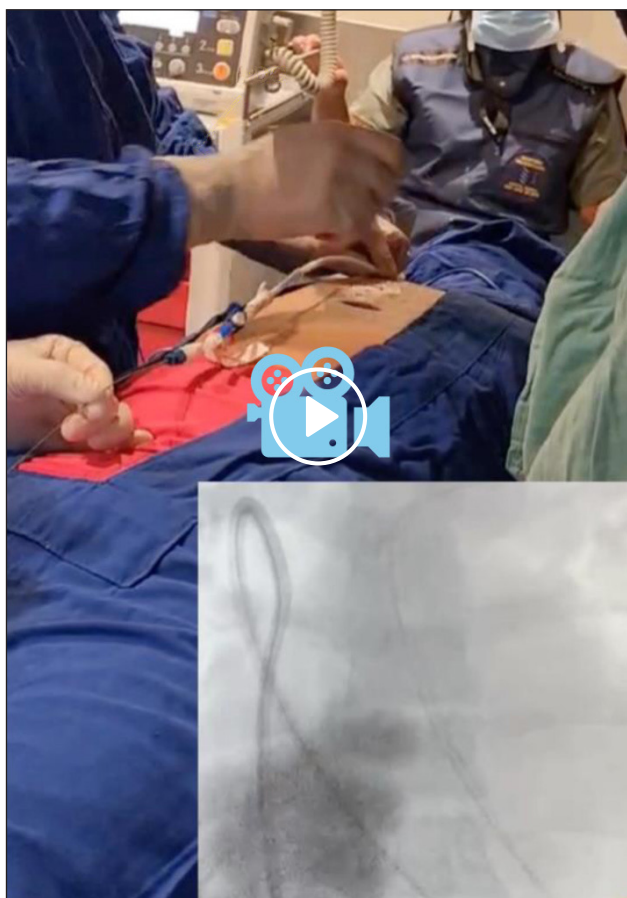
(A) Ultrasound-guided puncture of the right internal thoracic vein. (B) Passage of catheter and HSG to the pulmonary arteries. (C) Final position of the PDC. HSG: high-support guidewire, PDC: permanent dialysis catheter
